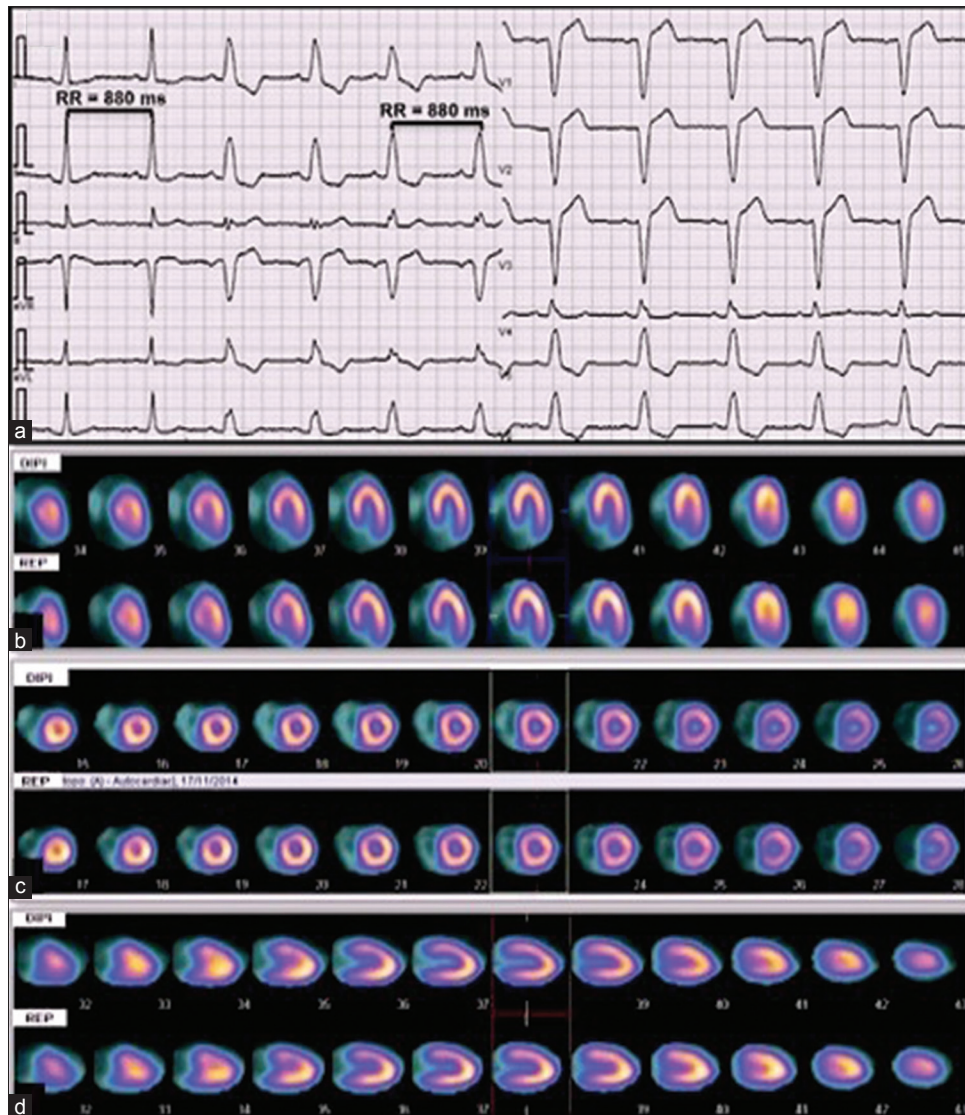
(a) Development of left bundle branch block during dipyridamole infusion without previous modifications in heart rate (see similar RR intervals before and after left bundle branch block morphology). Poststress and resting gated-single photon emission computed tomography images during 2 days stress-test protocol in short (b), long vertical (c) and long horizontal axis (d) showed no perfusion defects
